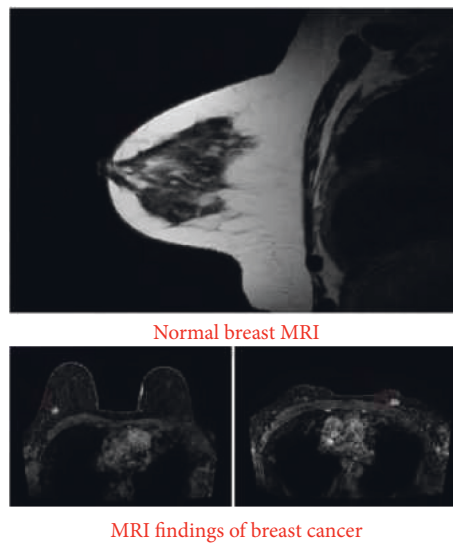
Plot of MRI images of sick patients compared with MRI images of healthy people.
